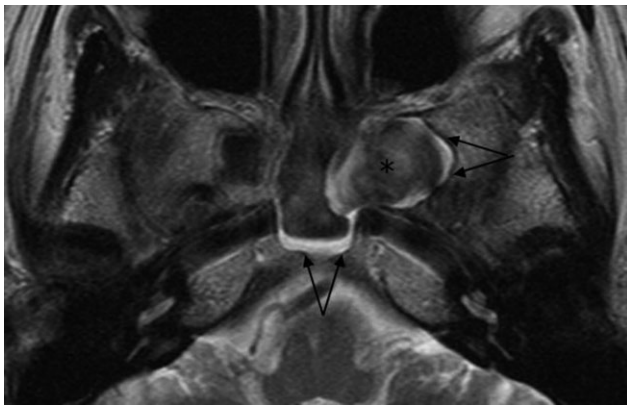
A fungus ball located within the left sphenoid sinus characterized by a hypointense signal on the T2-weighted magnetic resonance image (asterisk). Thickened mucosa lining the sinus wall is visible as a continuous hyperintense signal (arrows).
